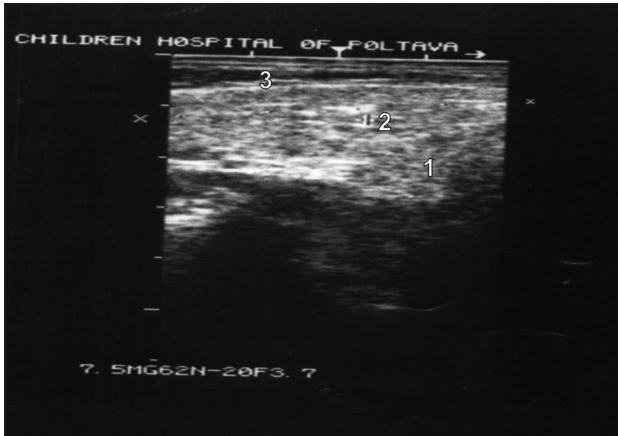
Ultrasound image of the right parotid gland. The image shows a small number of small, scattered sialectases (1), compaction of parenchymal tissues around them (2) and compaction of the gland capsule (3)
